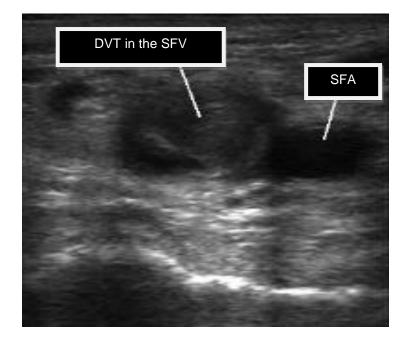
A B-mode ultrasound Image of a DVT in the transverse plane of the superficial femoral vein (SFV) (Grimm & Manson, 2011). The SFV is distended, non-compressible and filled with echogenic thrombus that appears grey on the ultrasound image. The superficial femoral artery SFA on the right of the image appears anechoic (black) on the ultrasound image.
